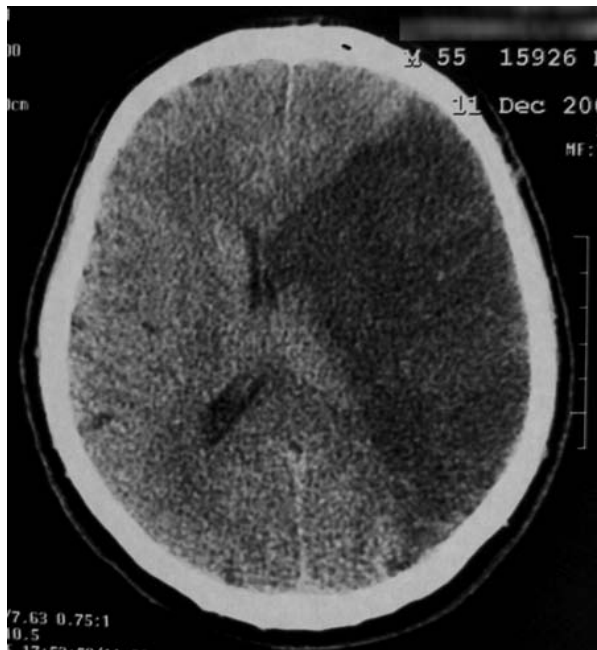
Samples of CT-scan.
